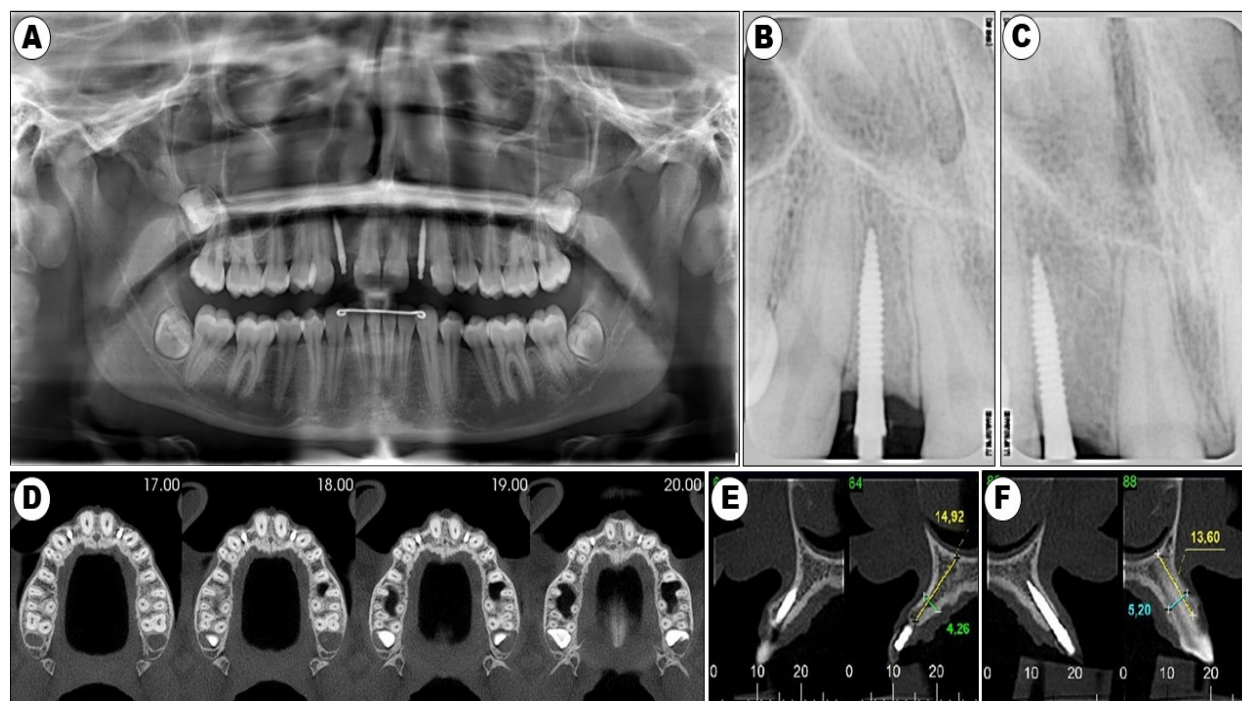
A: Initial panoramic radiograph showing the presence of two temporary intraosseous implants in regions 12 and 22 B: Periapical radiographs of temporary implants region 12 C: Periapical radiographs of temporary implants region 22 D: Computed tomography - Axial tomographic sections show horizontal bone availability and the presence of temporary intraosseous implants E: Sagittal tomographic sections showing bone height of 14.92 mm and thickness of 4.26 mm in region 12 F: Sagittal tomographic sections showing bone height of 13.60 mm and thickness of 5.20 mm in region 22
